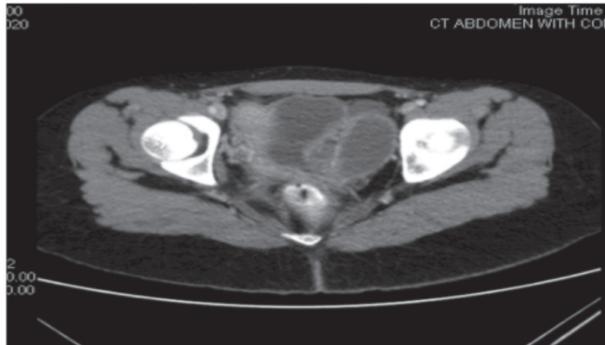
Abdominal Pelvic CT Scan Revealing Left-Side Pelvic Multilocular Fluid Collection
